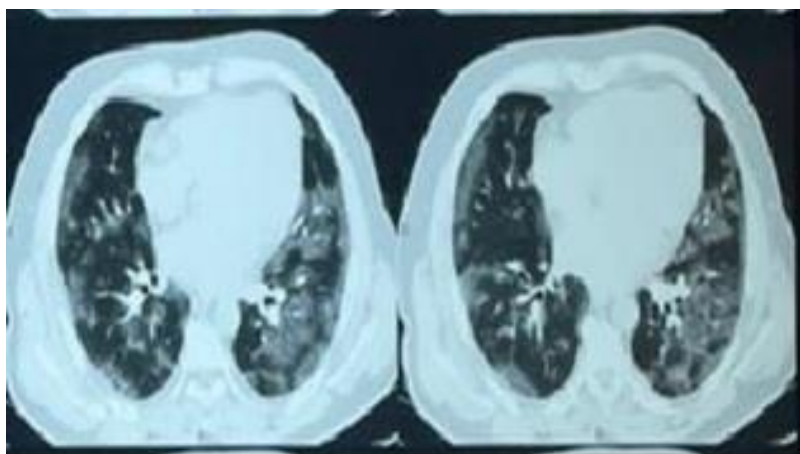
Chest computed tomography scan of the patient on admission to the ICU
